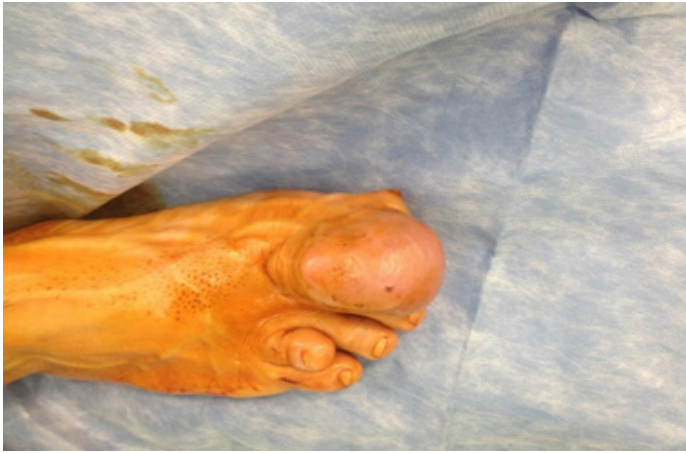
Pre-operative photograph of the patient to multiloculated lesion about 65x36x39 mm with calcifications around distal phalanx and extending laterally in computed tomography scan (Figure 3).
